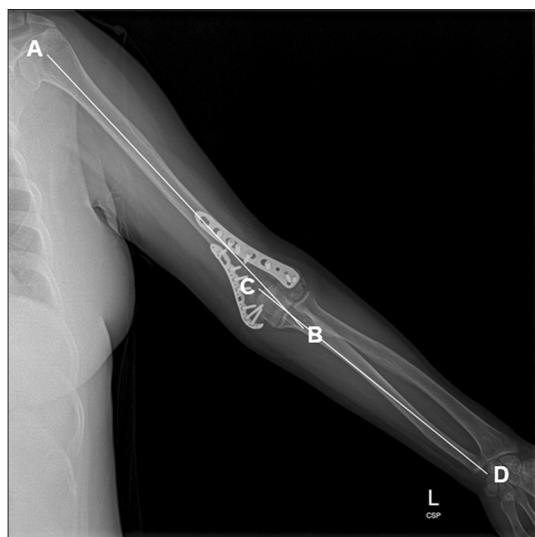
Measurement of carrying angle. The carrying angle was determined by measuring the angle between the longitudinal axes of the humerus (A, B) and the ulna (C, D) on a plain radiograph (anteroposterior view) of the elbow that included the humerus head and the wrist.
